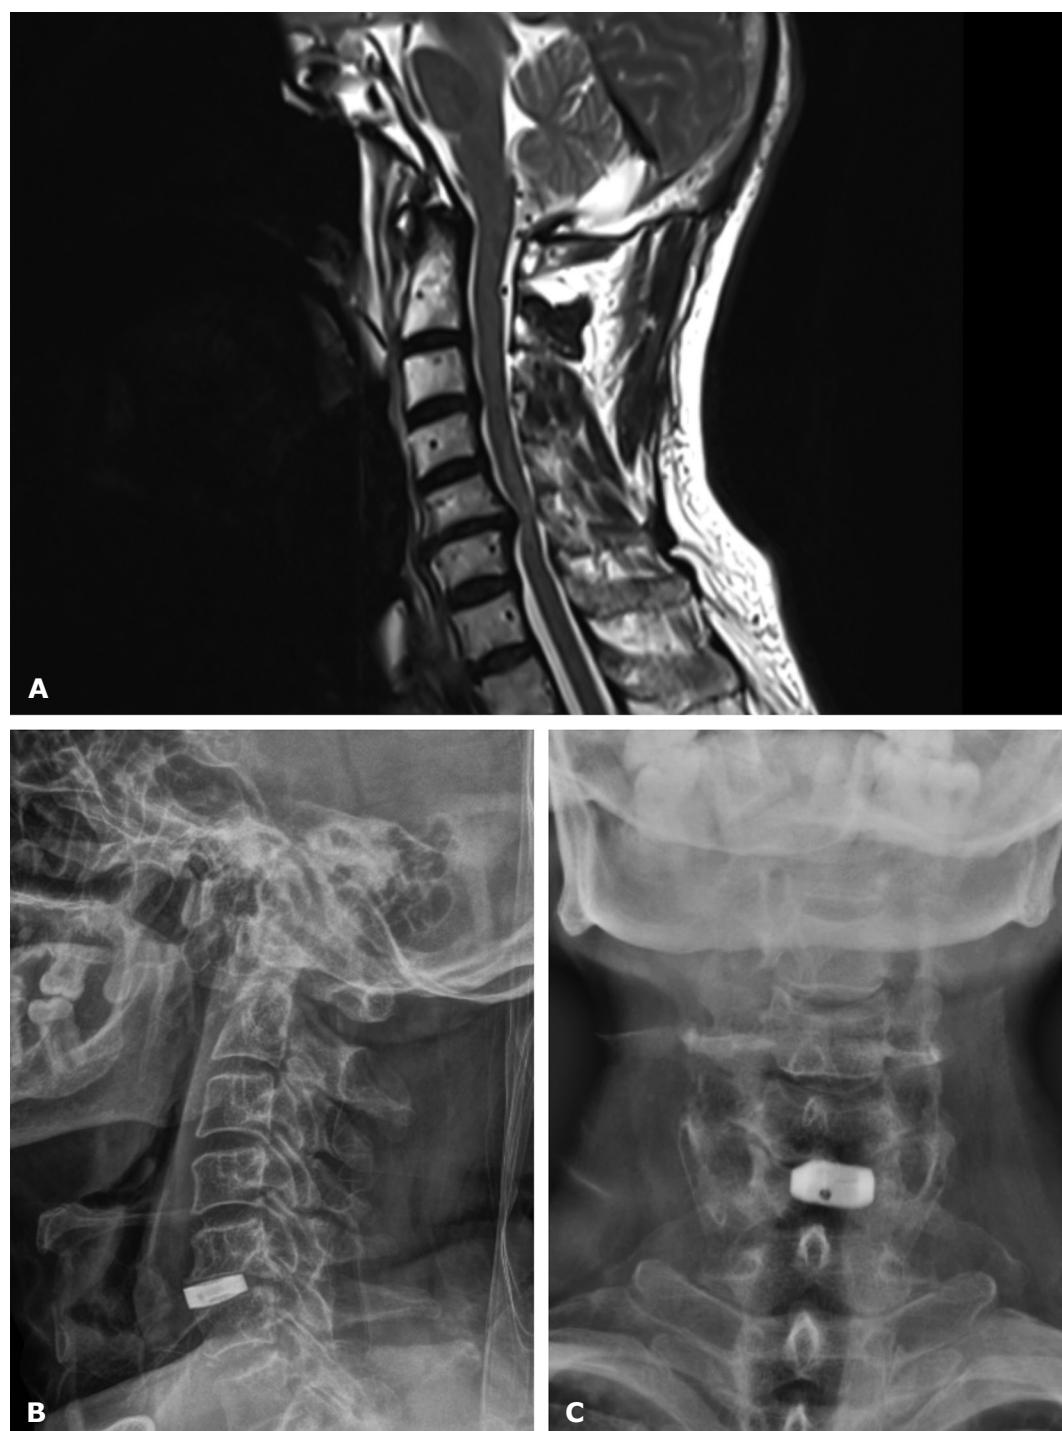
A - Preoperative magnetic resonance study of the cervical spine (T2 weighted image, sagittal view) showing cervical compressive myelopathy with disc osteophyte complex; B - Postoperative radiographic imaging study of the cervical spine (sagittal view) showing the cage *in situ*; C - Postoperative radiographic imaging study of the cervical spine (coronal view) showing the cage *in situ*
